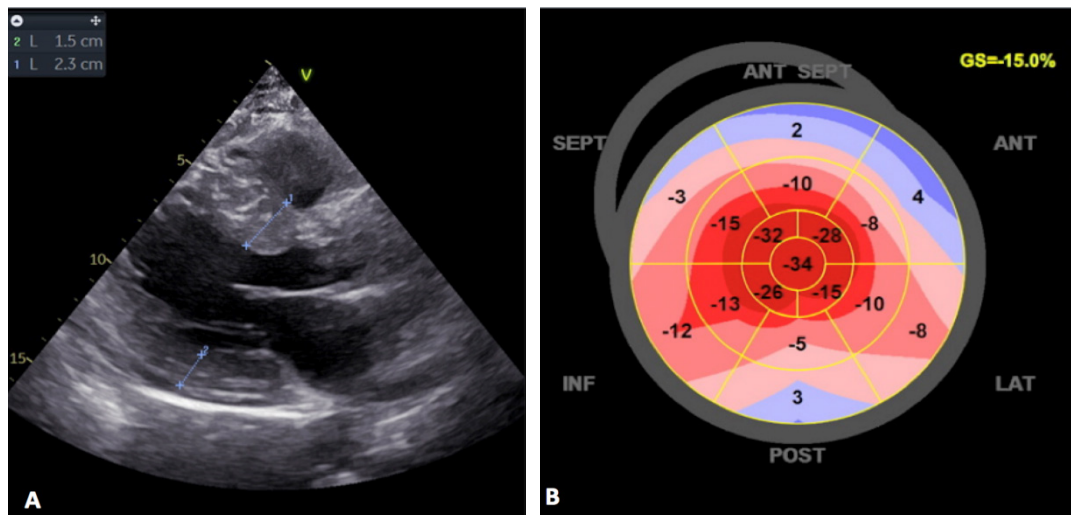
Transthoracic echocardiography showing increased left ventricular wall thickness (A) and the typical apical sparing (B).
